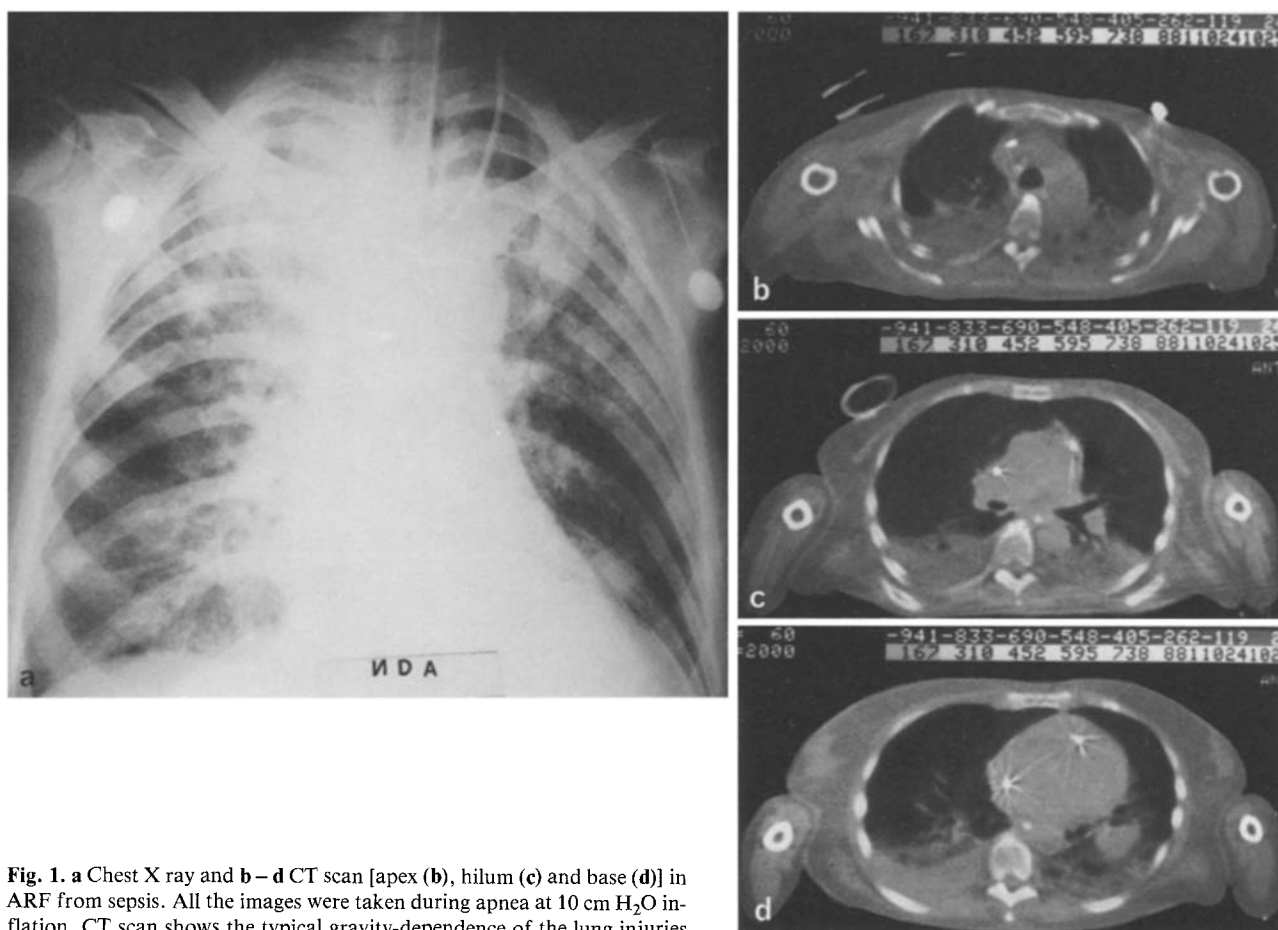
a Chest X ray and b–d CT scan [apex (b), hilum (c) and base (d)] in ARF from sepsis. All the images were taken during apnea at 10 cm H₂O inflation. CT scan shows the typical gravity-dependence of the lung injuries
